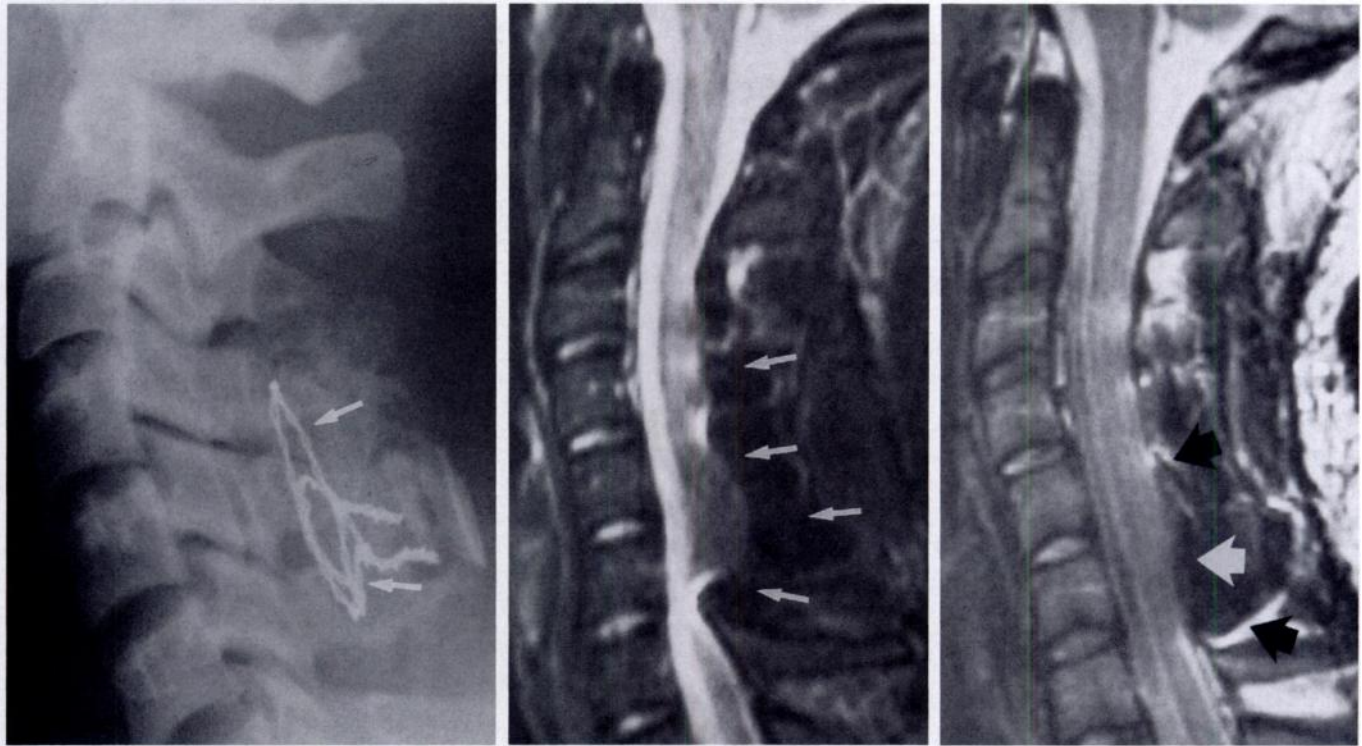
Posterior fusion wires. (a) Lateral plain radiograph of the cervical spine shows posterior fusion wires (arrows) extending from C-4 to C-6. (b) Sagittal T2-weighted SE MR image (TR msec/TE msec = 2,000/80, two signals averaged, 256 × 128 matrix, 4-mm-thick sections, examination time = 8 minutes 56 seconds) of the cervical spine shows marked distortion of the posterior aspect of the canal and cord by metallic artifact (arrows). (c) Sagittal T2-weighted FSE MR image (2,000/102, two signals averaged, echo space = 17 msec, echo train length = eight, 256 × 256 matrix, 4-mm-thick sections, examination time = 2 minutes 12 seconds) at the same location shows marked improvement in the amount of distortion (arrows) compared with b.
